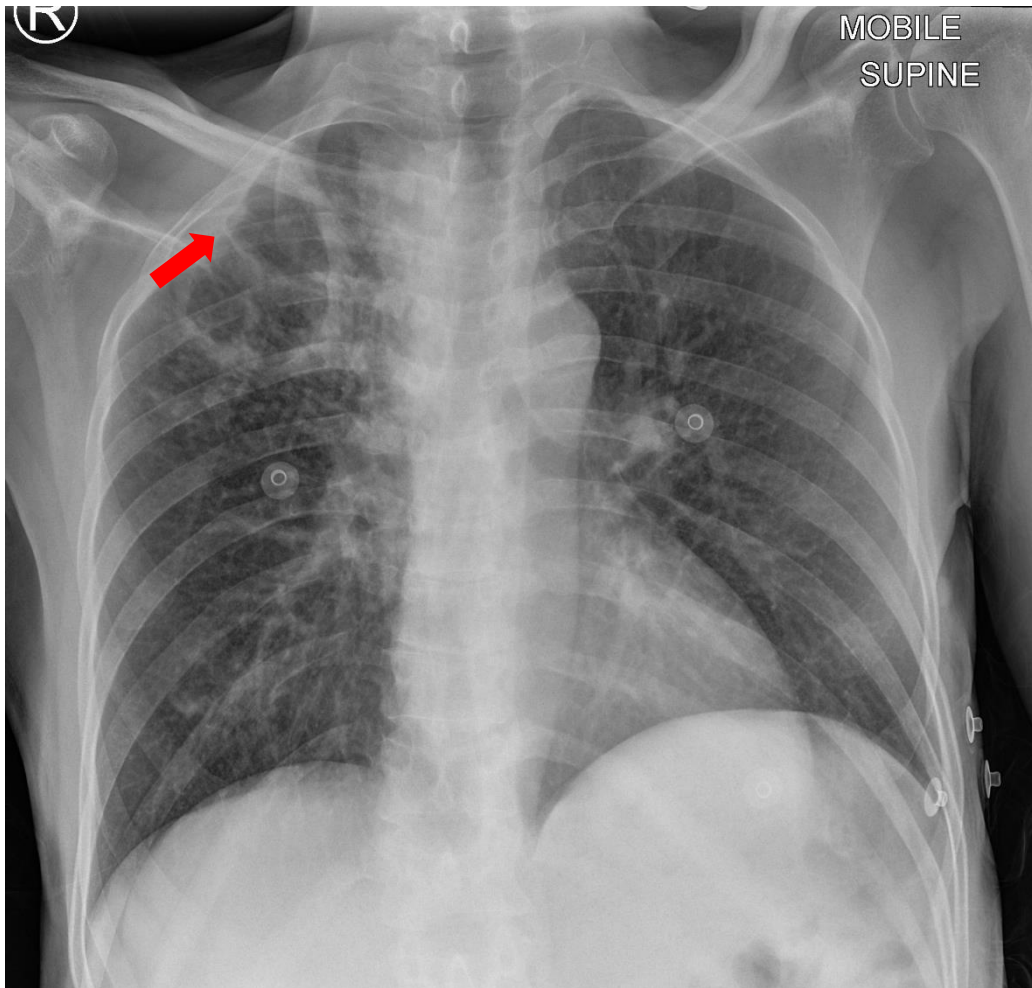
Frontal chest X-Ray showing a right upper lung zone thick wall cavitary lesion (Red arrow) associated with surrounding innumerable 1-2 mm. In addition, there is a right lower lung zone ill-defined airspace opacity with a subtle nodularity.
